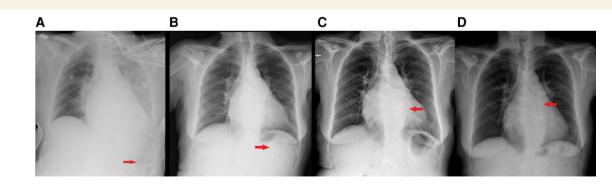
Chest radiographs (uncropped). (A) Chest radiograph taken in the intensive care unit \sim 24 h after surgery in 2018, showing temporary epicardial pacing wire fixed to the skin by a needle. (B) Chest radiograph before discharge in 2018, showing foreign body below the diaphragm. (C) Chest radiograph taken at index admission (2021), showing the foreign body projected at the level of the cardiac silhouette. (D) Chest radiograph taken a week after index admission, revealing further migration of the foreign body.
